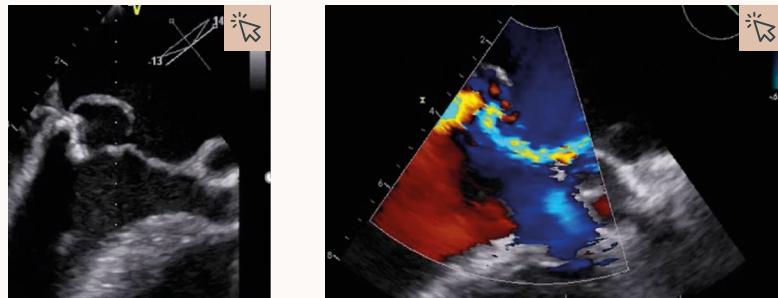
Baseline transoesophageal echocardiograms showing the flail leaflet (left) and eccentric jet (right).²⁷
